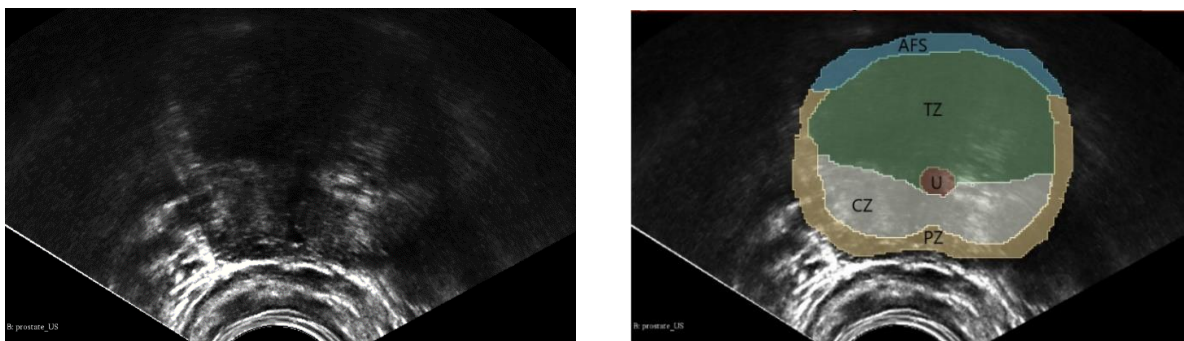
Prostate ultrasound image (*left*) with labelled zonal anatomy registered and overlaid (*right*).
